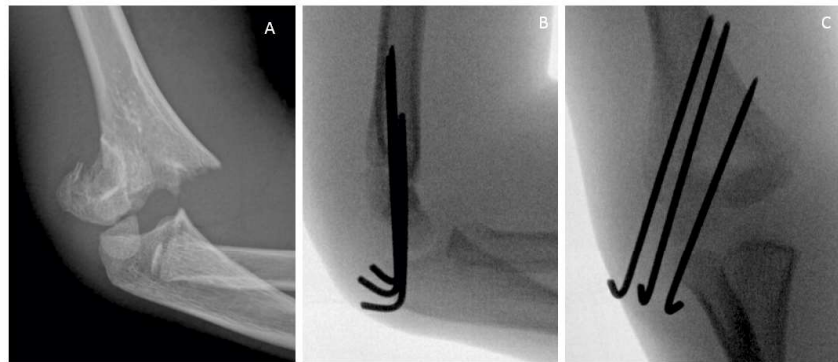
Lateral radiograph at injury (A), lateral (B), and AP (C) radiographs after closed reduction and lateral percutaneous pinning of a displaced and rotated Gartland Type 3 fracture.
